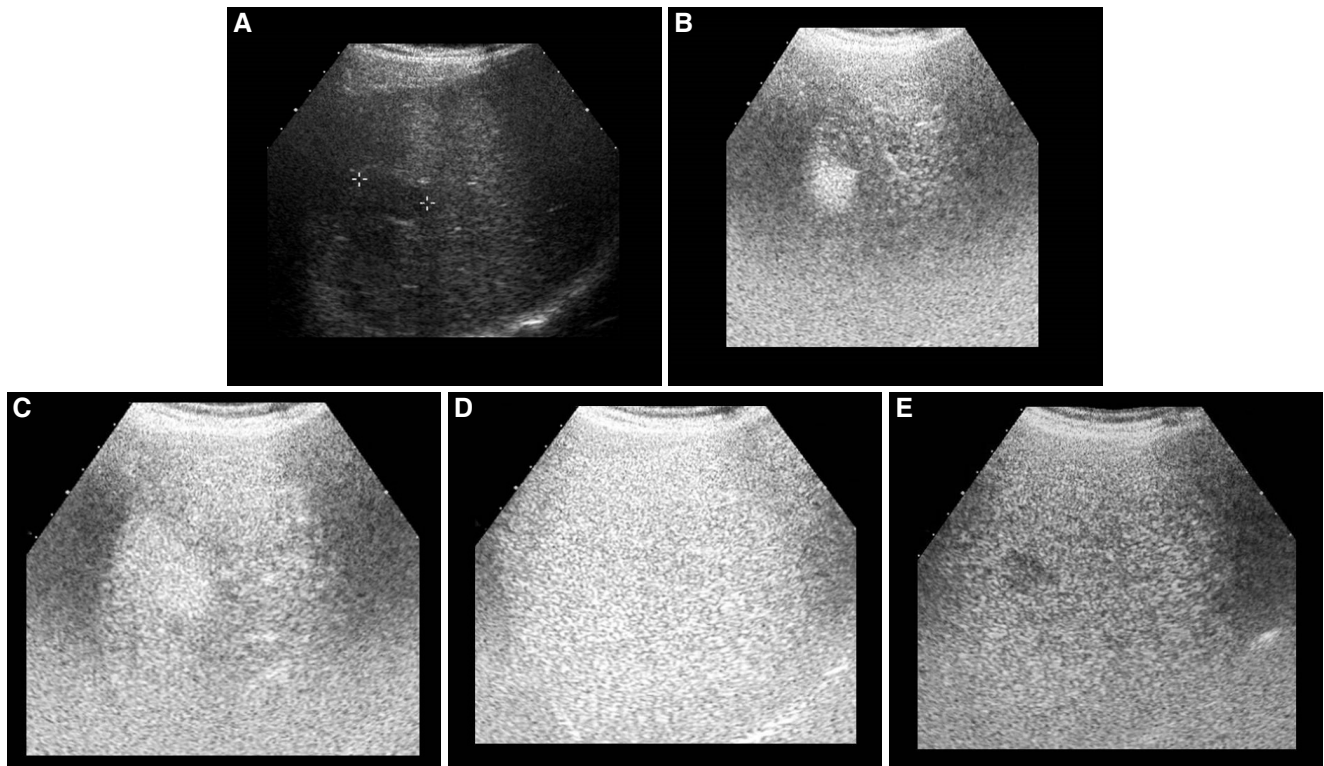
Abdominal ultrasound (A) and with contrast at 23 s (B), 30 s (C), 1 min (D), and 5 min (E). Hypoechoic lesion in right hepatic lobe corresponding to hepatocellular carcinoma with a typical vascular pattern: early uptake in arterial phases (B, C), isoechogenic respect to surrounded liver parenchyma in portal phase (D) and wash-out contrast in late phase (E)
